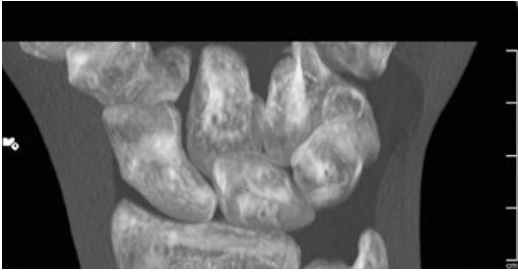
Inconspicuous computed tomography: maximum intensity projection (MIP)
